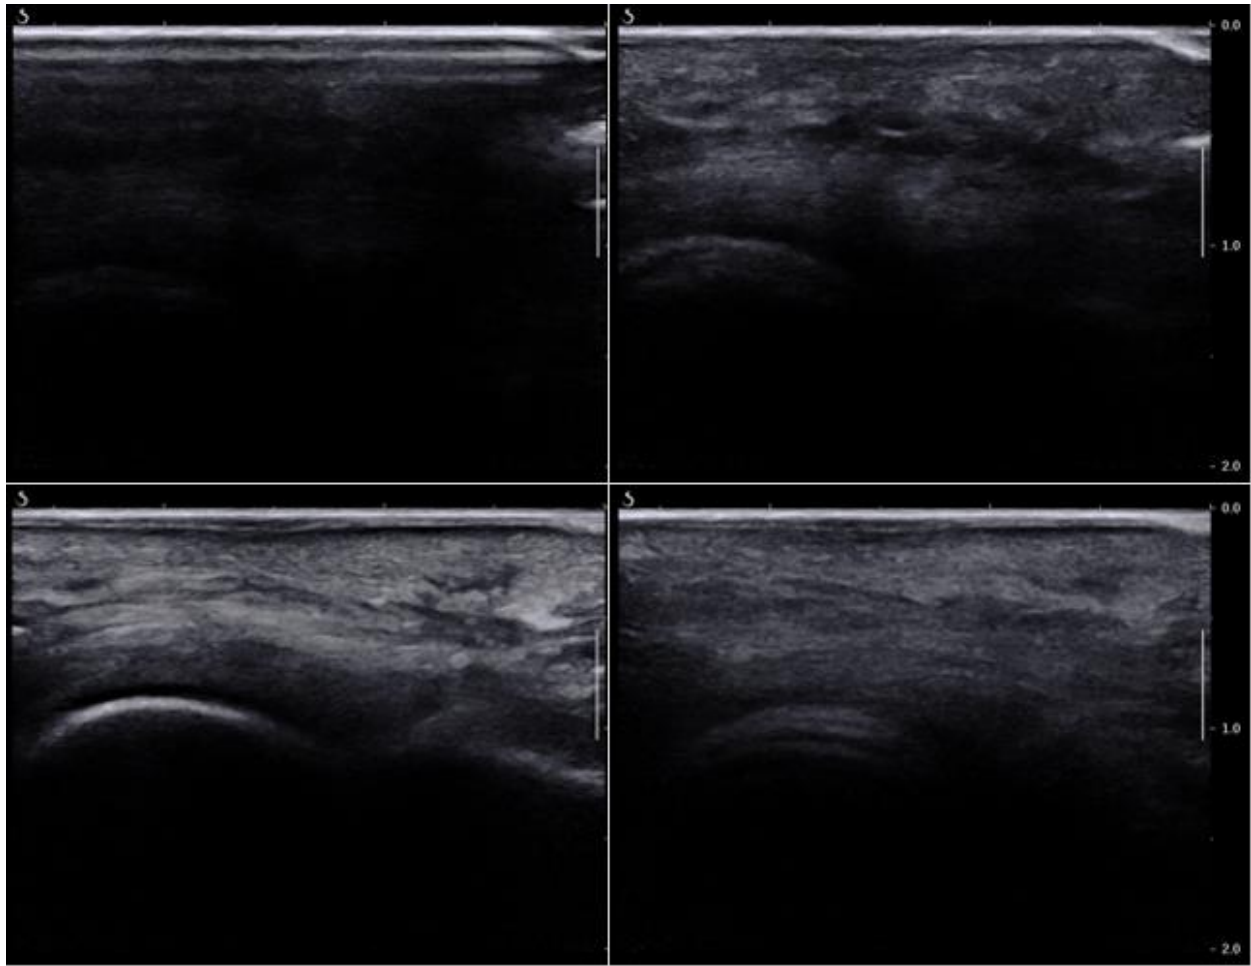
Ultrasound samples of a forefoot trial. Step start (top left), loading (top right), peak deformation (bottom left), and unloading (bottom right).
